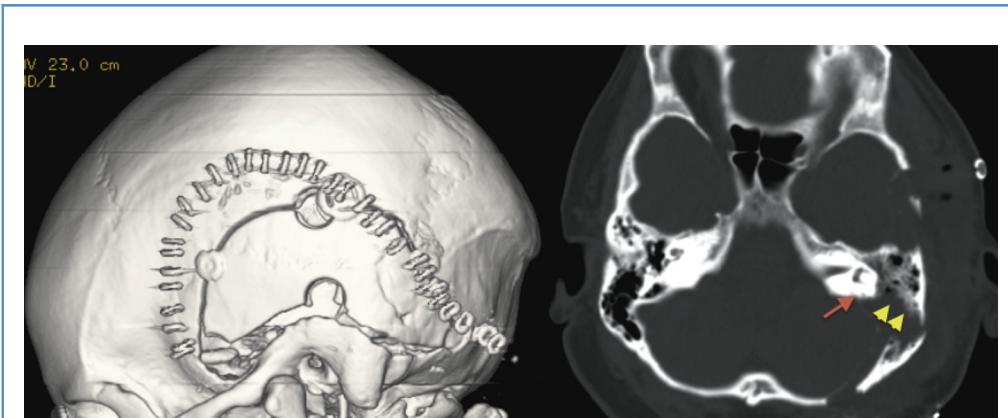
The postoperative computed tomographic bone reconstruction showed the area of craniotomy and temporal bone drilling. The minimal bone drilling allows the surgery to be faster and safer (yellow arrows). Red arrow, the inner ear structures that were left intact.
